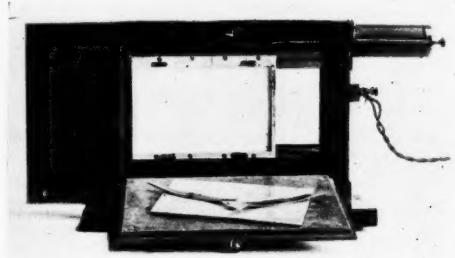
X-ray sensitometer, or exposing machine, rear view.
